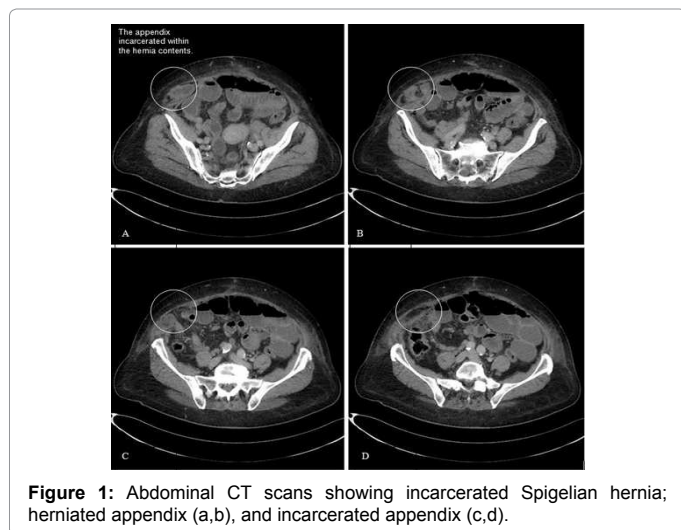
Abdominal CT scans showing incarcerated Spigelian hernia; herniated appendix (a,b), and incarcerated appendix (c,d).
